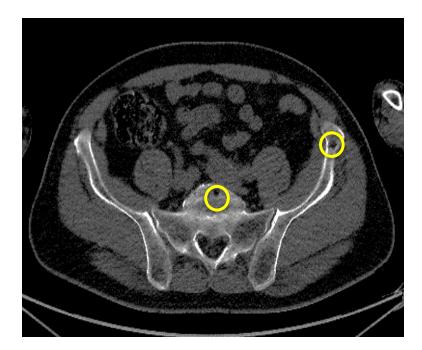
A single CT cross-sectional image through the pelvis at the level of the sacroiliac joints. This image demonstrates two osteolytic myeloma lesions.
